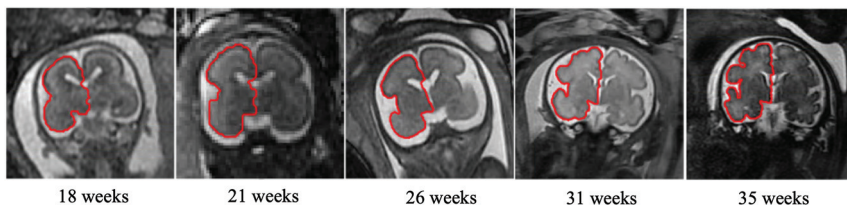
T2-weighted MR imaging of coronal views for control fetuses demonstrating gyrification development of the right hemisphere (red, *hemisphere contour*) at the Sylvian fissure level with gestation.
